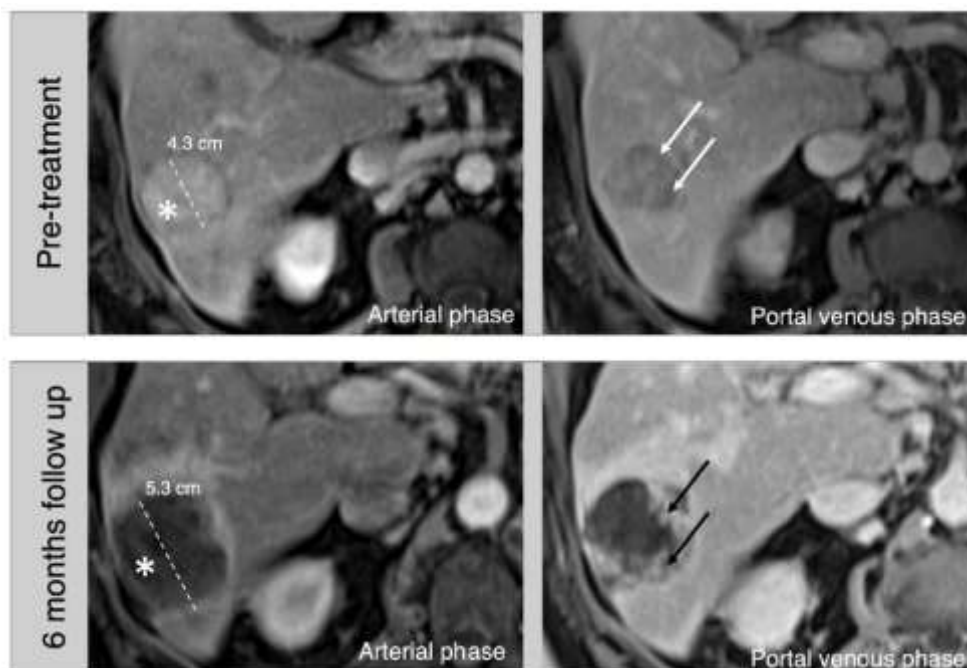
76-year-old male, hepatitis C cirrhosis, MR images. On pretreatment images, a 4.3 cm arterial phase hyperenhancing (*asterisk*) observation with portal venous phase washout (*arrows*) in the right lobe is consistent with HCC (LR-5). Follow-up images 6 months after Y-90 radioembolization shows a larger appearance of the mass due to treatment changes. The lack of arterial phase hyperenhancement (*asterisk*) and irregular progressive enhancement on portal venous phase (*black arrows*) are consistent with posttreatment changes (LR-TR Nonviable) [27].
